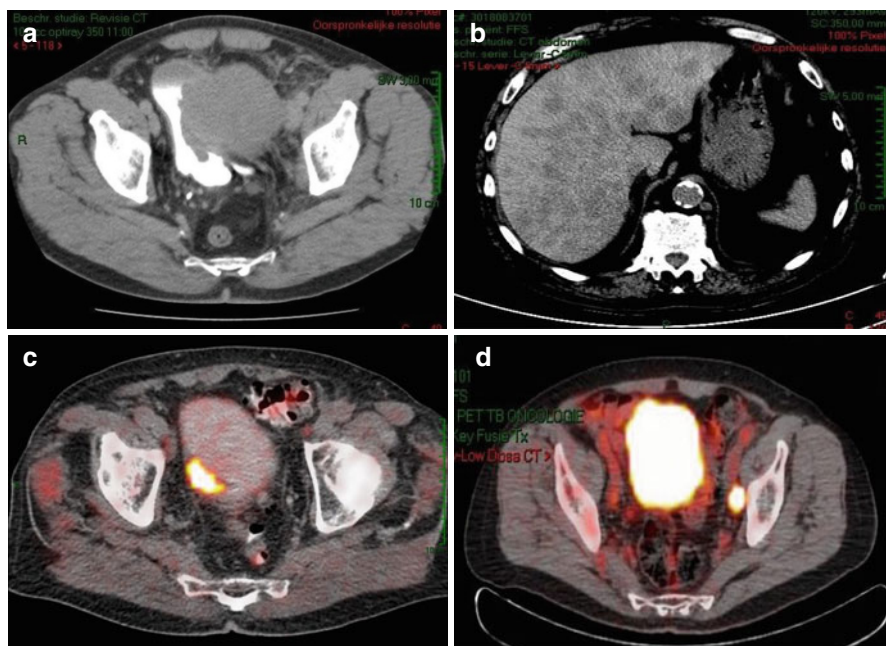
Computed tomography (CT) of the abdomen demonstrating a large small cell carcinoma of the bladder (SCCB) with extravesical extension (a); CT of the abdomen with extensive liver metastasis at diagnosis in a patient with extensive disease stage (b); fluorodeoxyglucose (FDG)-positron emission tomography (PET) of a primary SCCB after image attenuation for physiological excretion in the urine (c); FDG-PET in a patient with limited disease stage demonstrating pelvic lymph node metastasis
